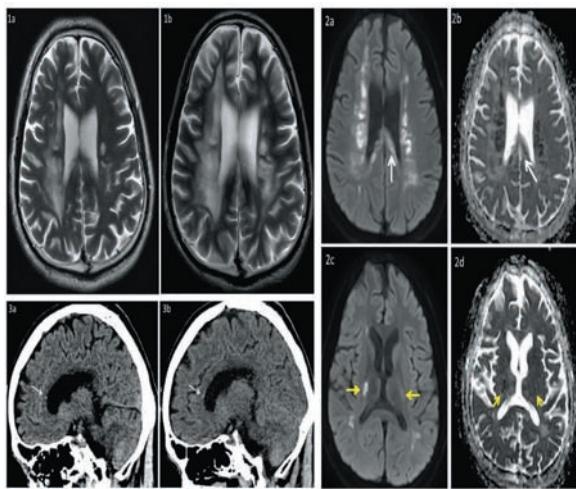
Axial T2W MR image at the first presentation. Asymmetric periventricular, deep white matter and subcortical T2 hyperintensities seen, appearing more confluent on the right. Background cerebral involutorial changes and ventricular prominence appear advanced for age.
